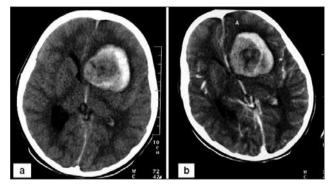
9-year-old boy with left frontotemporal AT/RT (Case-1). A, Precontrast CT scan shows slightly hyperdense large tumor causing midline shift with peripheral hemorrage, and minimal intraventricular bleeding in the 3rd ventricle. B, Postcontrast CT scan at the same level shows no enhancement of the mass.
